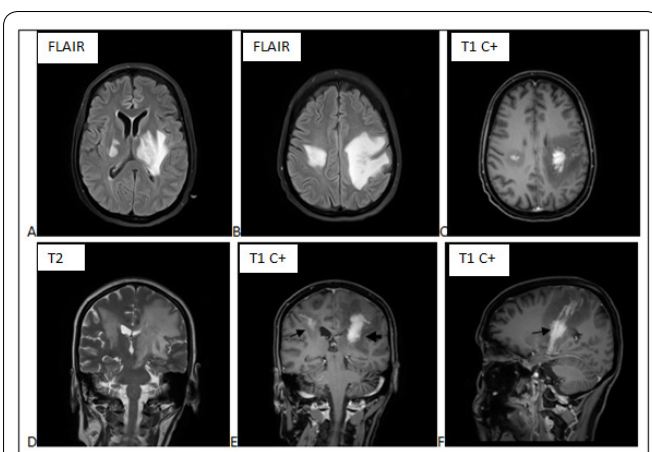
Follow up magnetic resonance images of brain after 7 weeks, T2FLAIR axial sequences A and B- T2 weighted coronal image D- showing increase in the hyperintense lesion over bilateral subcortical white matter (left > right). Post contrast T1 axial C- coronal E- and sagittal F- showing contrast enhancing lesion over bilateral white matter tracts (black arrows).
